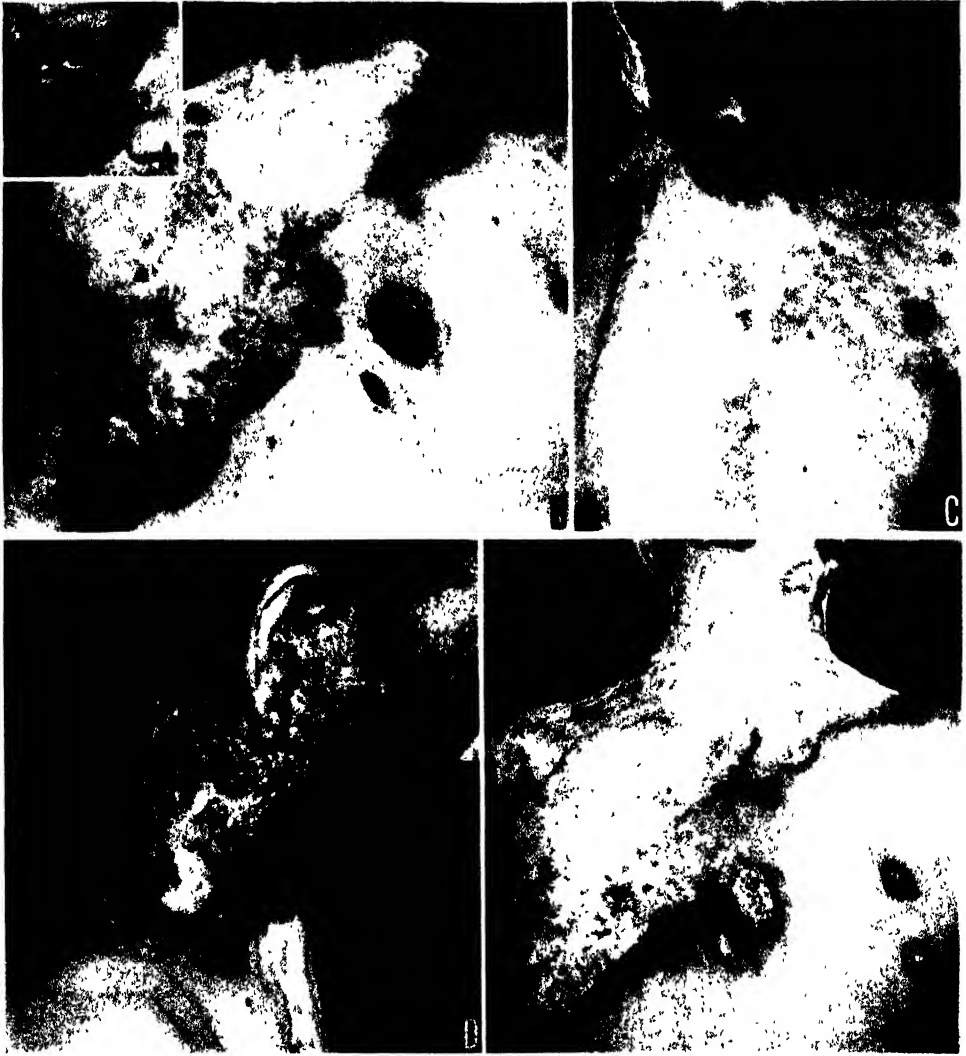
Blastomycosis: infection of 15 years' duration with widespread involvement of the skin. There was no evidence of internal dissemination of the infection. *A, B* and *C*, active verrucous and fungating lesions with extensive scarring after healing. The disease was present on the face, including the eyelids. The scar tissue on the neck prevented free motion of the head. *D* and *E*, marked involution of the lesions six weeks after beginning intensive internal therapy with potassium iodide and roentgen irradiation of the lesions.
